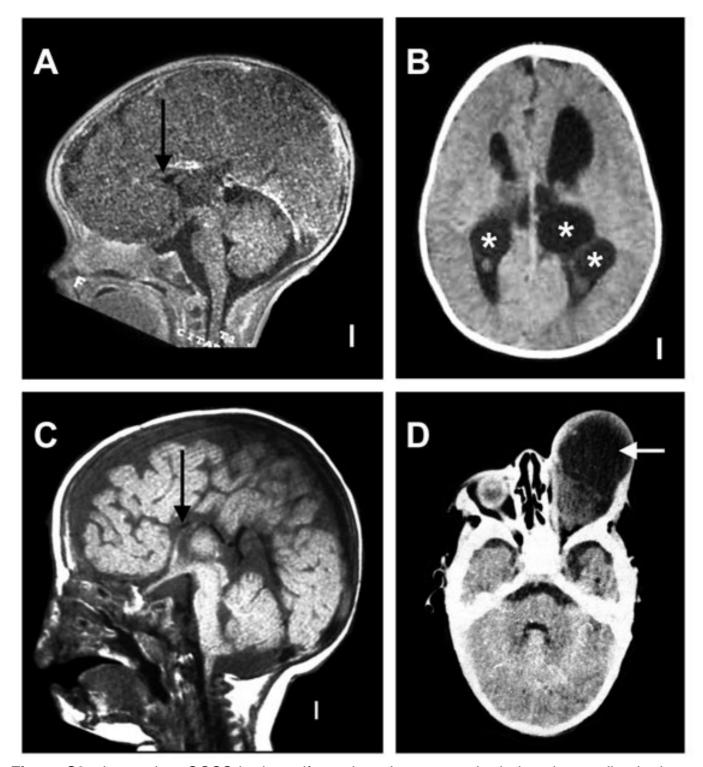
Incomplete OCCS brain malformation. In contrast, brain imaging studies in three OCCS patients were also suboptimal and incomplete, but showed less severe malformations. These consisted of an old MRI in patient 9 (A-B), a single MRI mid-sagital image in patient 10 (C), and a few CT images through the posterior fossa (D) in patient 11. The gyral pattern appears normal on limited views in patients 9 and 10 (B and C). The lateral ventricles are mildly enlarged and separated with several intraventricular cysts in patient 9 (asterisks in B), but cannot be assessed in patients 10 or 11. The corpus callosum is absent save for a small anterior remnant in patient 9 and completely absent in patient 10 (black arrows in A and C). The brainstem including the tectum, and the cerebellum appear normal in all three patients (A, C and D). The left eye is cystically enlarged in patient 11 (D).
